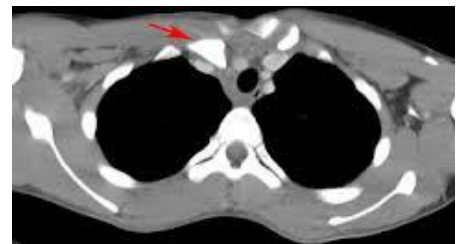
CT image showing a posterior SC dislocation.
